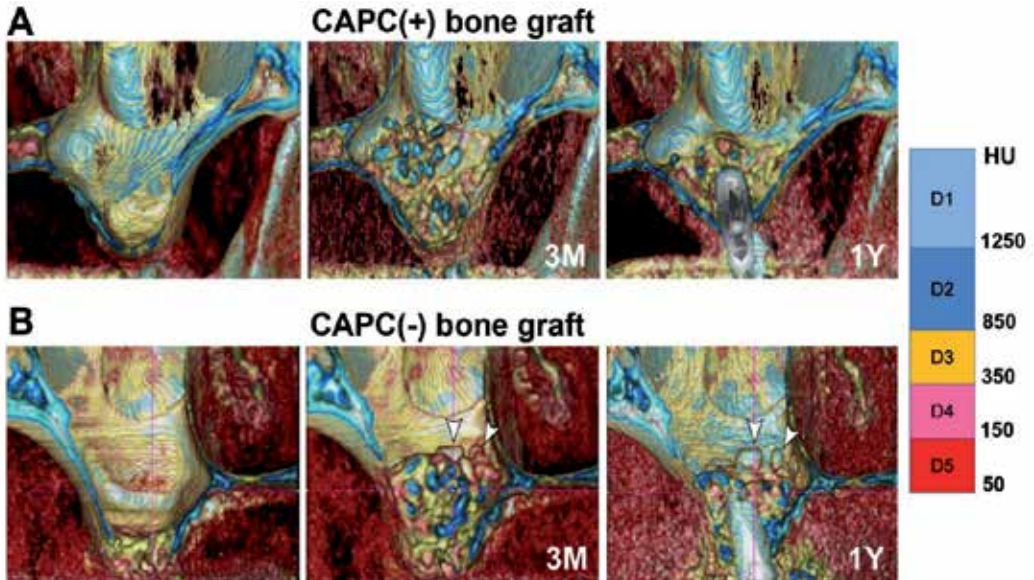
CT images of the maxillary sinus constructed from DICOM data before surgery and at 3 months (3M) and 1 year (1Y) after CAPC(+) bone graft or conventional CAPC(-) bone grafting. Color mapping of the images according to bone density as determined by Hounsfield units (HU) for CT data was applied. In the graft material at 3M, many areas are depicted in light blue (D1) and blue (D2), which is indicative of autogenous cortical bone particles (A and B).
